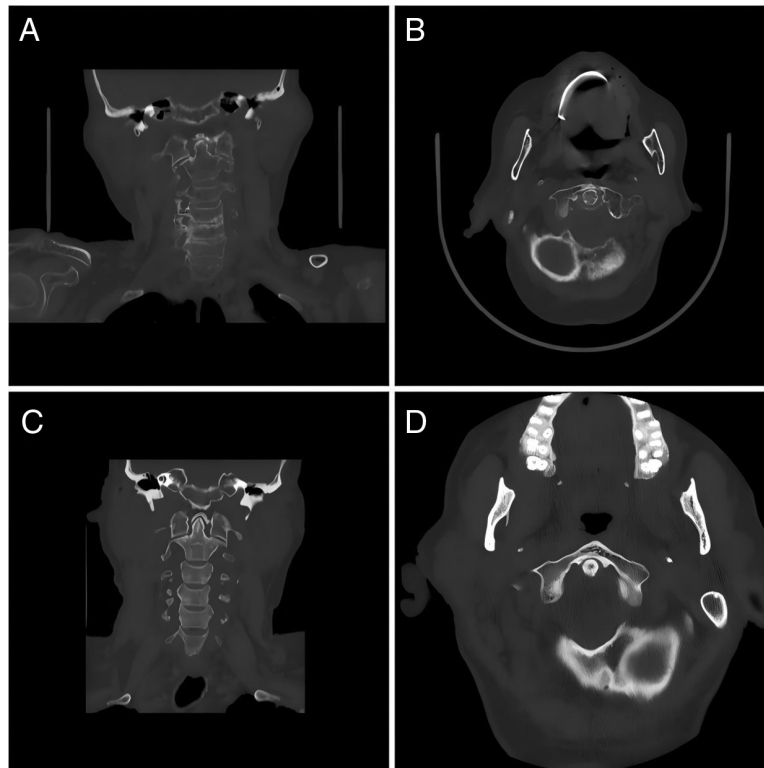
CT images of case 1 and case 2. Panels (A) and (B) display images from case 1, demonstrating calcific deposits located along the posterior and right superior aspects of the odontoid process. Panels (C) and (D) show images from case 2, revealing calcifications distributed at the anterior and superior aspects of the odontoid process. CT = computed tomography.
